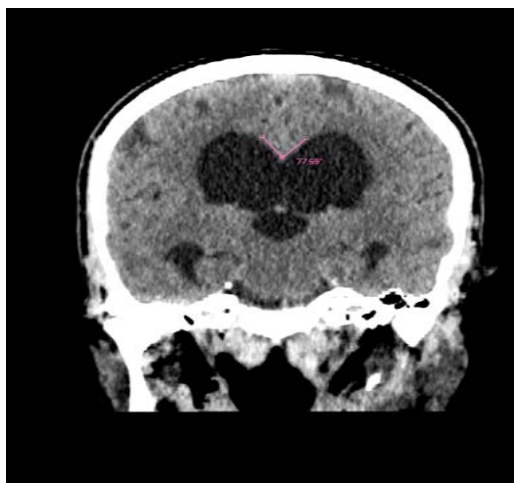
Coronal CT view: Acute Callosal-marginal angle
